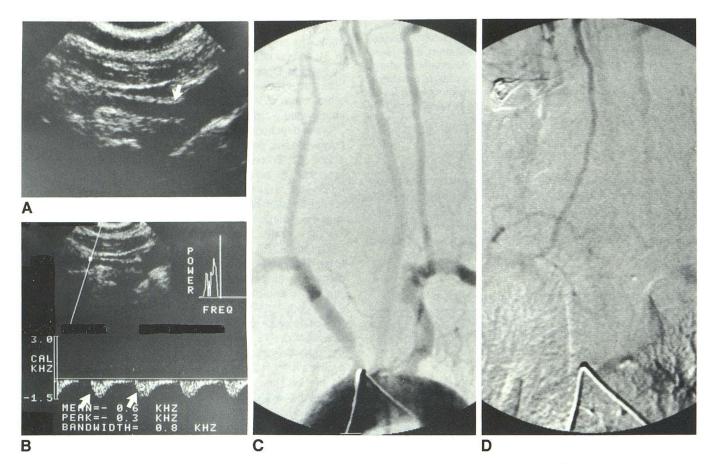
A, In this example, vertebral origin was unremarkable by imaging (arrow). B, Doppler waveform was reversed in direction and thus appeared
